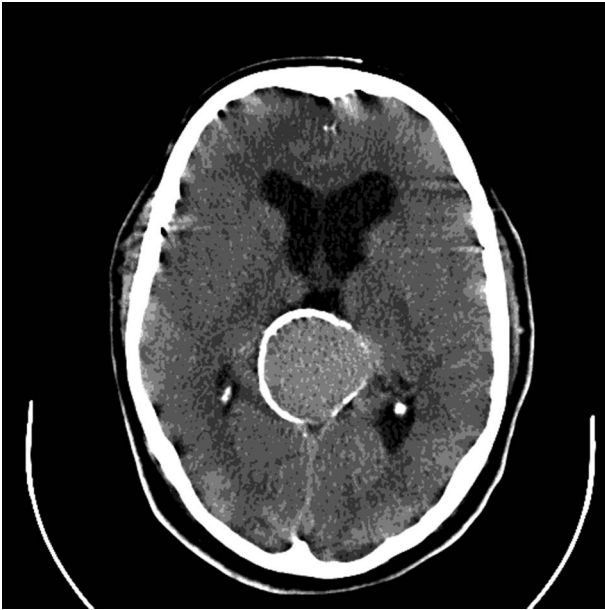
Axial CT brain scan showing aneurysmal malformation.
